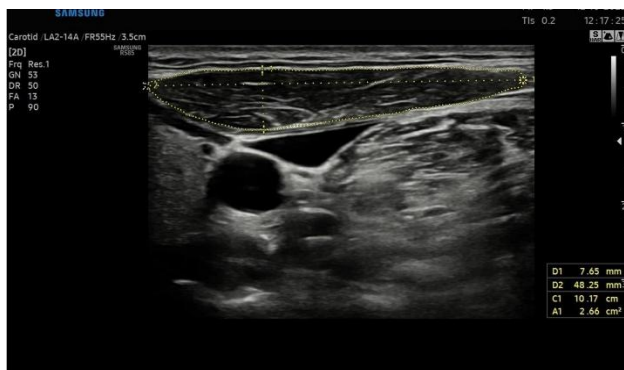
Cervical muscles' cross-sectional area from the ultrasound imaging
